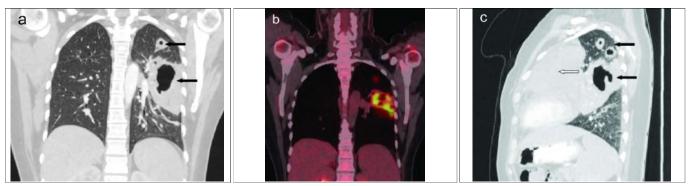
(a,b,c): CT scan of chest, coronal & lateral views showing cavitary lesions in both the lungs (2A & 2C, black arrows). Also, FDG-PET/CT scan showing FDG avid cavitary consolidation in the left upper lobe (2B) and multiple cavitary FDG-avid nodular opacities noted in the left lung (2B).
